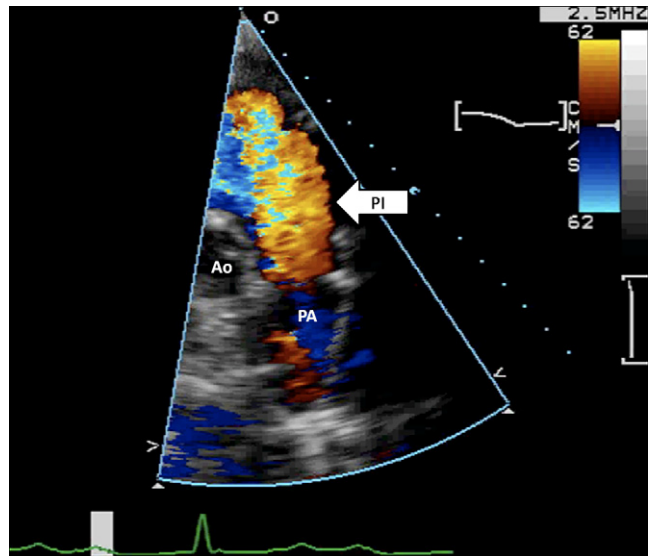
Transthoracic parasternal short-axis view at the basal level demonstrates severe PI by color Doppler. Ao, Aortic valve; PA, pulmonary artery.
